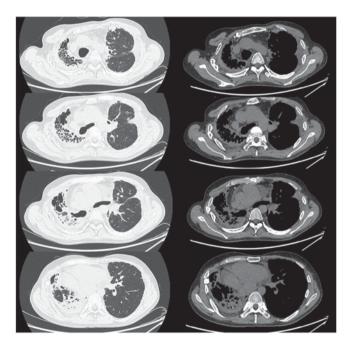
Axial CT performed at the time of admission to our hospital revealed diffuse pleural thickening, cystic bronchiectasis, dense subpleural opacification and volume loss associated with evidence of fibrosis involving the entire right lung including the lower zone. In the left lung, CT imaging indicated wedge-shaped interlobular pleural thickening distributed in the upper zone. CT, computed tomography.
